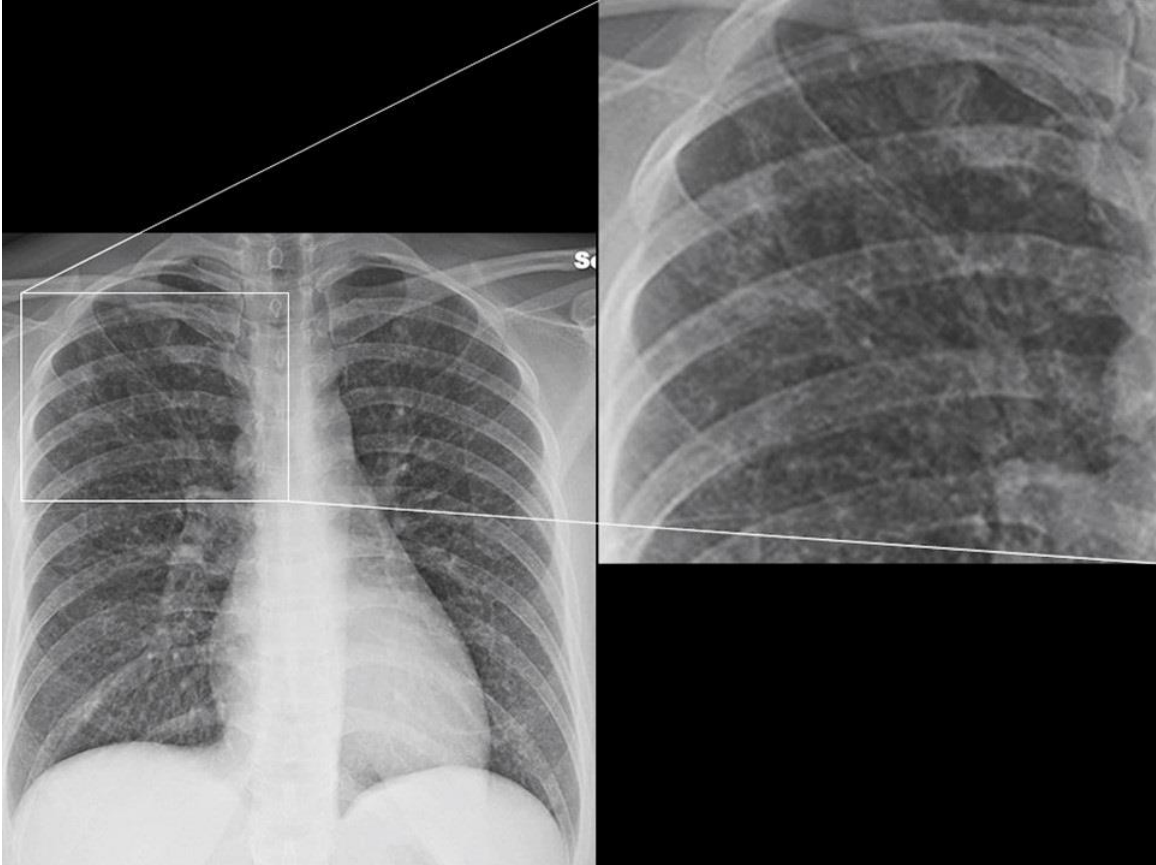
Magnified inset image from frontal chest radiography.
